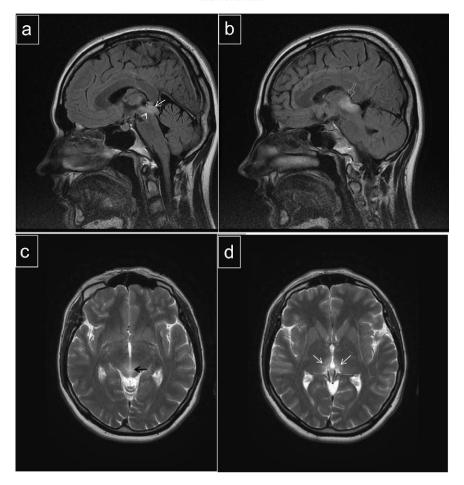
Midsagittal (a) and parasagittal (b) FLAIR images show increased signal in the superior two thirds of the tectum (arrow in panel a), dorsal portion of the mesencephalic tegmentum (arrowhead in panel b). Extension of the abnormal signal from mesencephalon into diencephalon is appreciated on the parasagittal image (hollow arrow in panel b). Panels c and d. Two consecutive axial T2 weighted images delineate involvement of dorsal medial thalamic area (mediodorsal nuclei) (white arrows in panel d), pretectal area and posterior commissure (black arrow in panel c).
